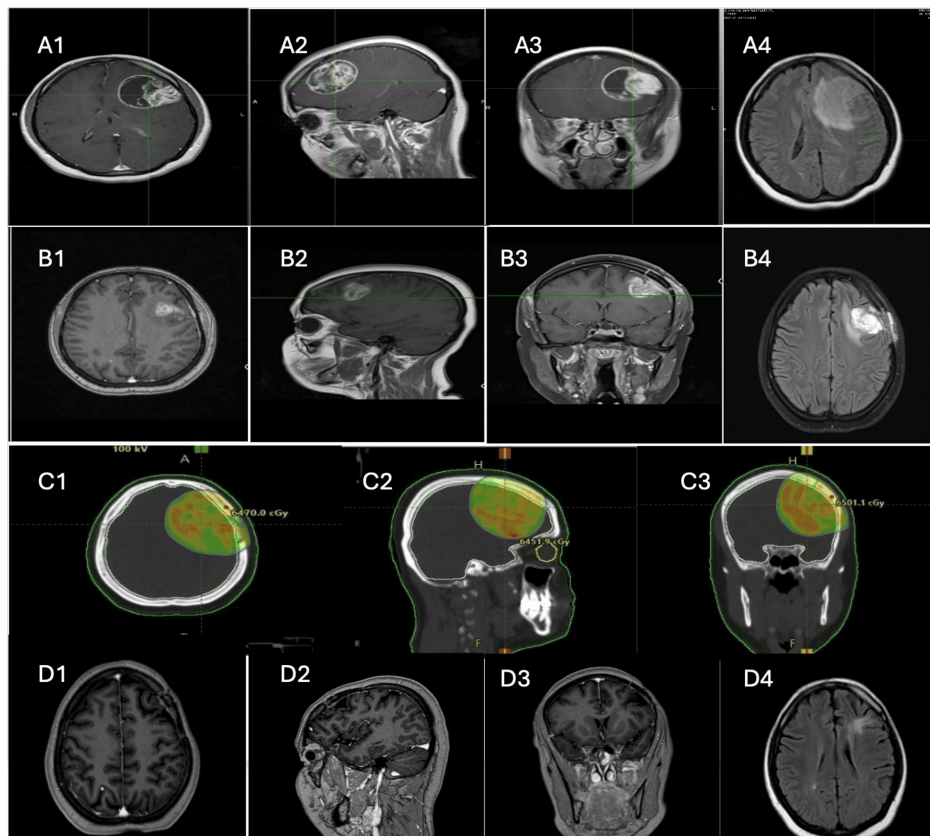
Preoperative, postoperative, last follow up MRI, and radiotherapy treatment planning
